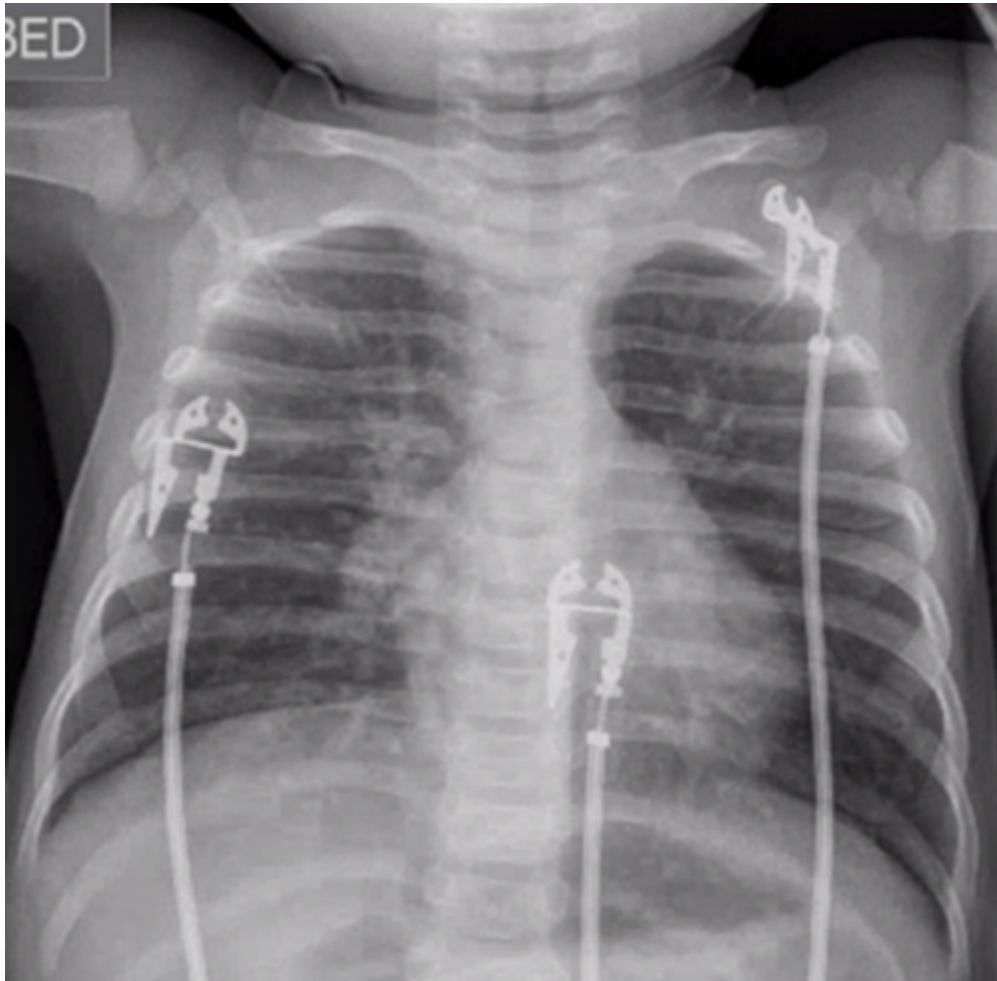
The initial chest X-ray shows peribronchial cuffing and infiltrative changes in the right perihilar and left infrahilar regions. ↩
